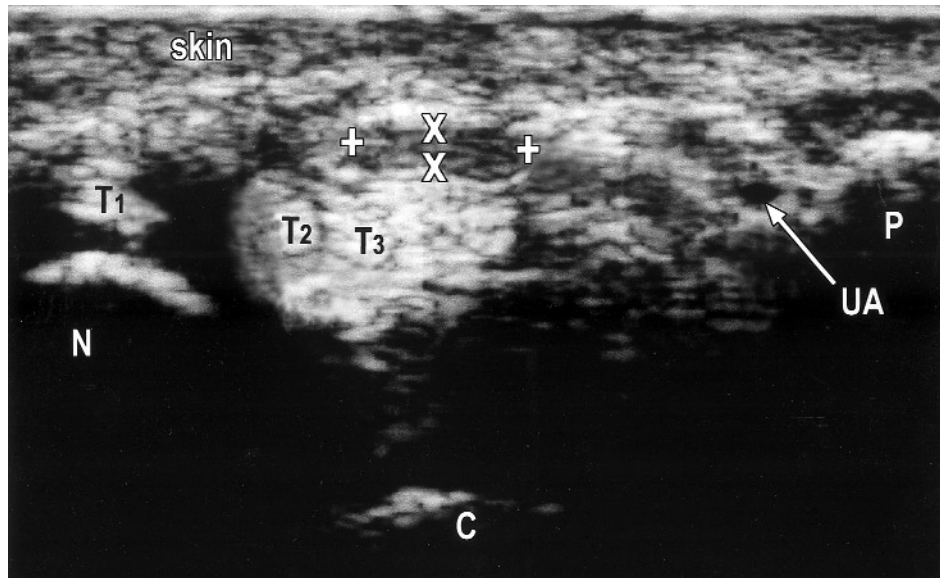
Transverse sonographic image of the entrance to the carpal tunnel with a normal median nerve.
